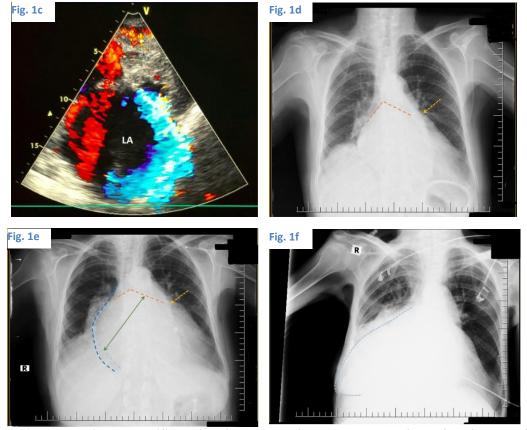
Figure 1a, 1b, and 1c; the modified apical 4 chambers views demonstrate giant left atrium and Color Doppler recording of the eccentric mitral regurgitation. Figure 1d, 1e, and 1f display progressively increasing cardio-thoracic ratio in the three chest x-rays taken in 2017, 2019 and 2021, respectively. Figure 1d and 1e show splaying of the carina with increased the tracheal bifurcation angle to over 90 degrees (the orange dashed lines) and convex left atrial appendage (the yellow arrow). A double density sign (dark blue dashed line refers to the right atrial border, the light blue left atrial) is observed in figure 1e, and the oblique measurement from the left main bronchi to the left atrial border is greater 7 cm (the green solid line). In figure 1f, the right chest side is mainly occupied by the giant left atrium (the light blue dashed line), leading to atelectasis and reduced lung capacity.
